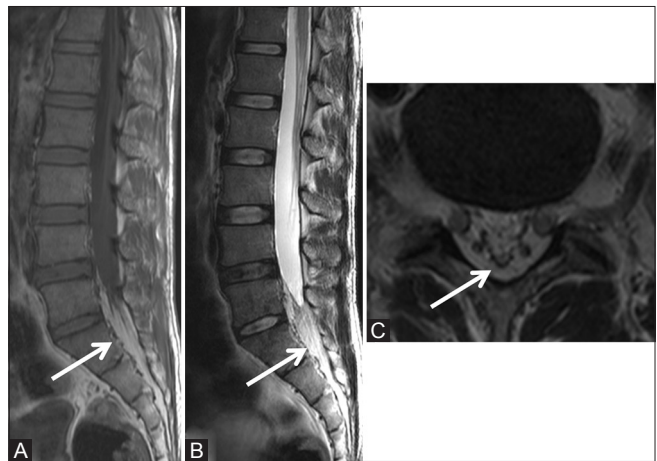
(A-C): Benign lesions: Epidural Lipomatosis: 36-year-old female with low backache. Sagittal T1-weighted (A), T2-weighted, (B) and axial T2-weighted (C) images showing excessive proliferation of epidural fat (arrow) below L5 level resulting in the deformation of thecal sac with its narrowing
